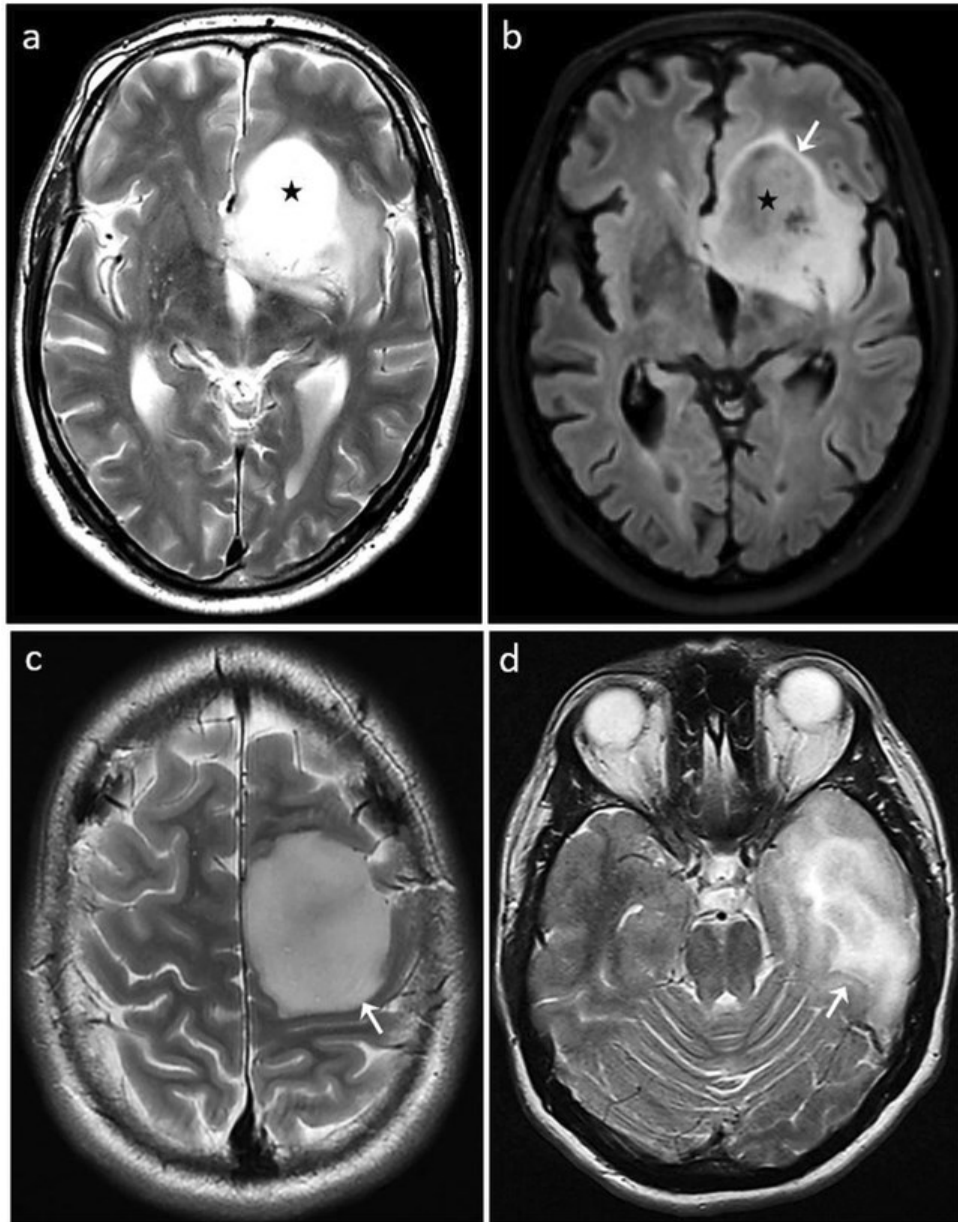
Representative cases: assessment of the T2-FLAIR mismatch sign, tumor margins, and T2 signal uniformity. T2-FLAIR mismatch sign (a, b; low-grade astrocytoma, *IDH*-mutant): Axial T2-weighted image shows a homogeneous hyperintense lesion in the left fronto-insular region (a, black star), while the FLAIR sequence reveals marked signal suppression except for a peripheral hyperintense rim (b, white arrow), consistent with the T2-FLAIR mismatch sign. Well-defined margins and T2 homogeneity (c; low-grade astrocytoma, *IDH*-mutant): Axial T2-weighted image displays a left frontal lesion with uniform hyperintensity and sharply defined borders (white arrow). Ill-defined margins and T2 heterogeneity (d; high-grade astrocytoma, *IDH*-mutant): Axial T2-weighted image demonstrates a left temporal lesion with heterogeneous signal and poorly defined margins (white arrow). Adapted from (Azizova et al., 2025b), licensed under CC-BY-4.0.
